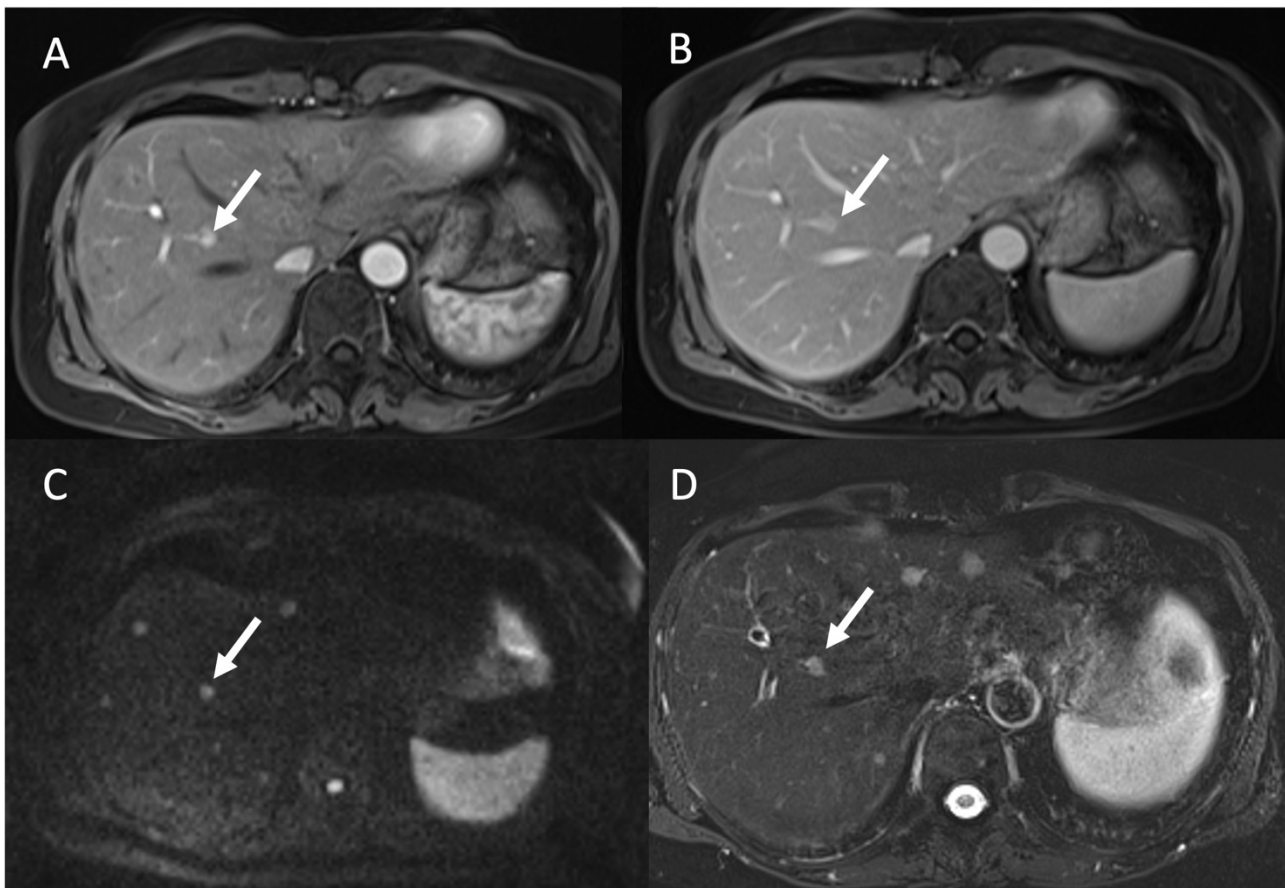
MRI evaluation of liver NEN metastases. Contrast study ((A): arterial; (B): portal phase) show a single lesion (arrow), while, in DWI (C) and T2-W FS (D), more lesions were detected compared to (A,B).
